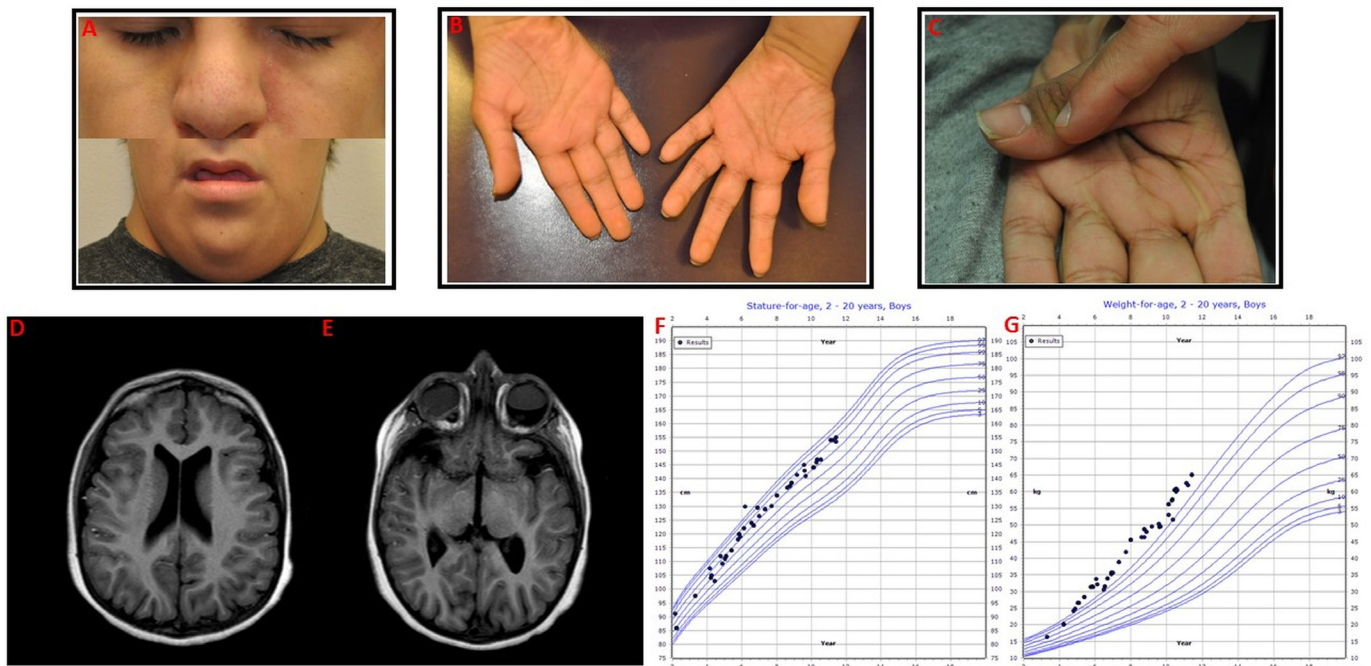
Phenotypic manifestations: (A) Small and upslanting palpebral fissures, smooth philtrum and micrognathia (consistent with DS); enophthalmos, elongated facies and no epicanthal folds (consistent with MFS). (B) Lack of brachydactyly, clinodactyly and single transverse palmar crease (observed in persons with DS). (C) Steinberg or thumb sign (when folded across palm, the distal phalanx of the thumb fully extends beyond the ulnar border of the hand). MRI images: (D) Axial T1 image demonstrating diffuse cortical atrophy, diminished quantity of the white matter volume and mild-moderate thinning of the corpus callosum. (E) Axial T1 image demonstrating prominent extra-axial spaces at the anterior temporal lobes and ex vacuo ventriculomegaly. Orbital vault is small, consistent with multiple prior ophthalmologic comorbidities. Patient's growth charts: (F) Height growth chart (90th percentile at 11 years of age). (G) Weight growth chart (>97th percentile at 11 years of age). Not pictured: pectus excavatum is poorly visualised due to obesity. DS, Down syndrome; MFS, Marfan syndrome.
